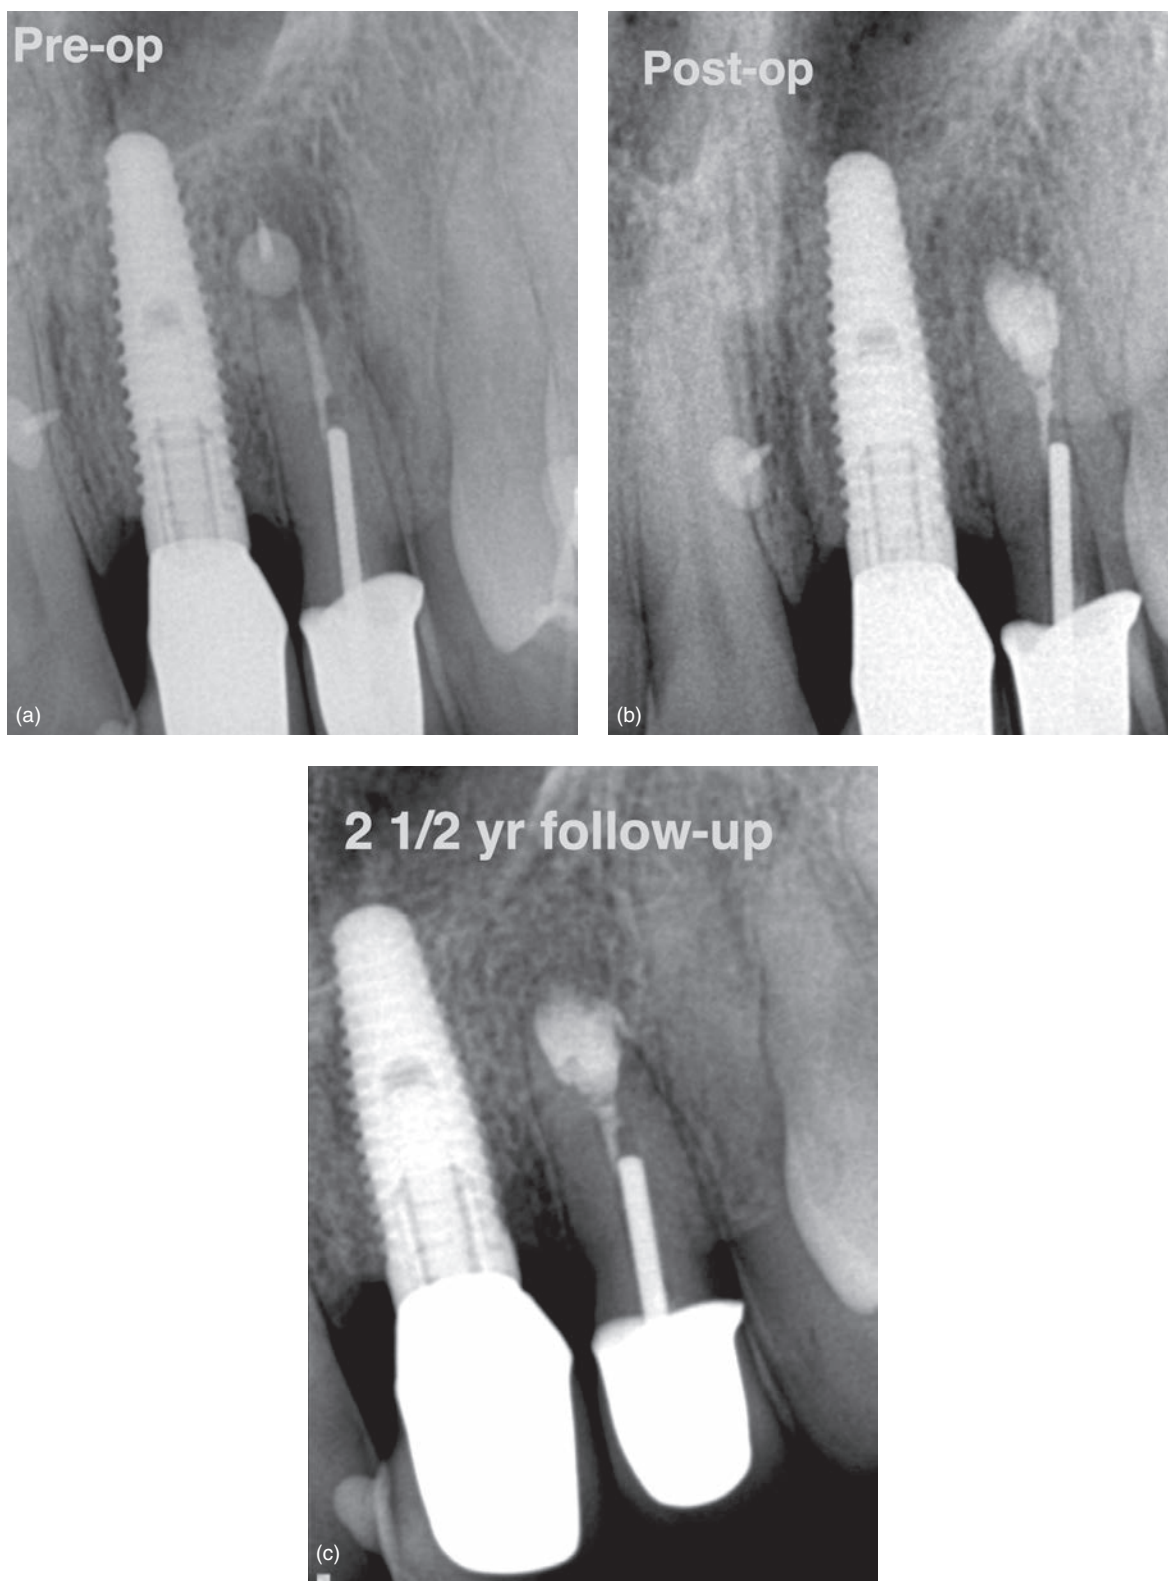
Apex of maxillary lateral incisor was resorbed due to misplaced bone tack used to stabilize the bone grafting membrane. (a) Preoperative radiograph showing apical periodontitis and a resorptive defect. (b) Bone tack was removed and root end surgery was performed. Root end and resorptive defect was filled with Bioceramic root repair material. (c) Two and a half year follow-up radiograph showing complete bone healing.
